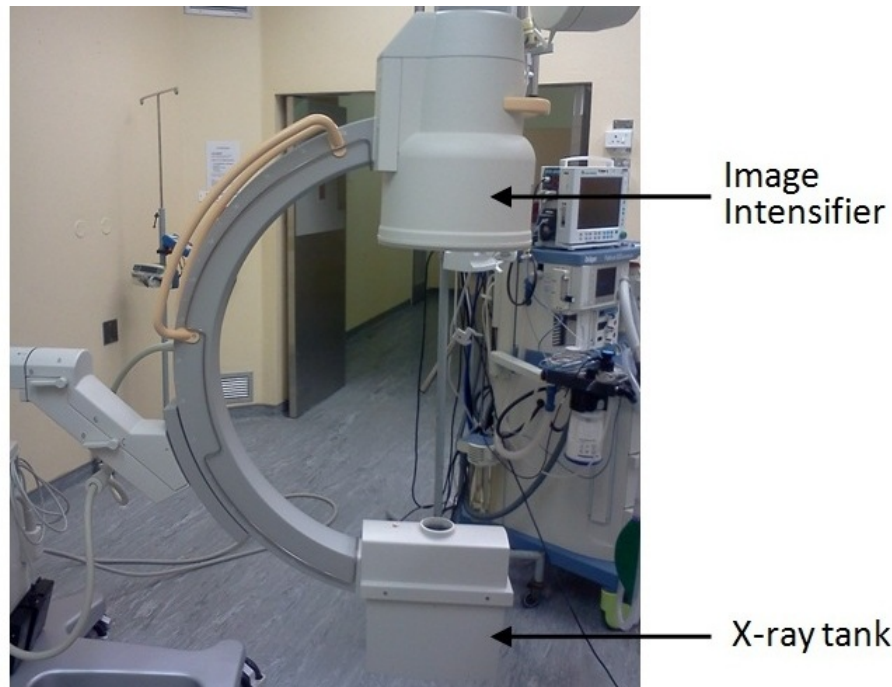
Photo of the *Philips BV Pulsera* showing the X-ray tank (XT) and the image intensifier (II)
